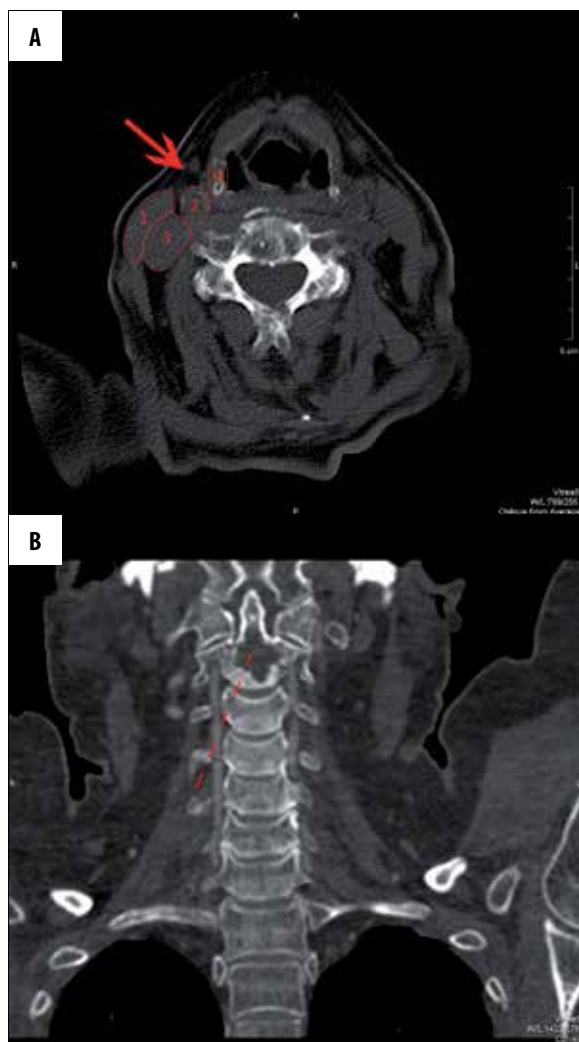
(A, B) CT examination (same patient as in Figures 1A–2D) before the procedure. Site of needle puncture and course of the needle are marked. Puncture was performed at the level of C4–C5 intervertebral disc at the level of C4 body after palpating common carotid artery pulse. The needle was directed medially to common carotid artery, toward the base of odontoid process, bypassing the vessels and penetrating through the muscles only (m. longus coli, m. longus capitis). Bone needle was introduced into the vertebral body followed by PMMA cement administration under careful x-ray guidance.
